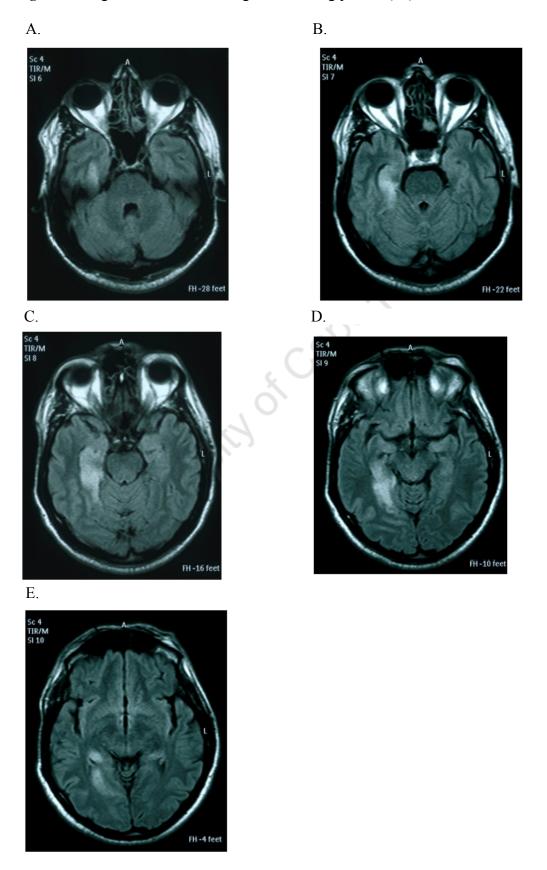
Magnetic Resonance Images: Non-dreaming patient (#6)
